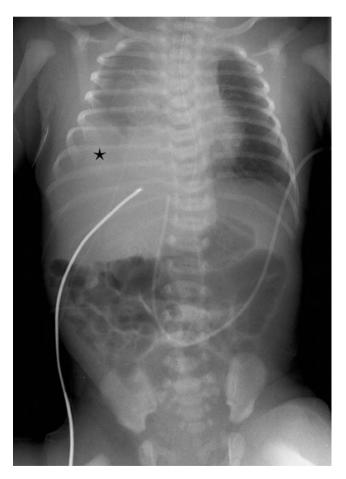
Radiograph of the chest and abdomen shows a small right lung with diffusely decreased aeration. A triangular opacity (*asterisk*) in the lower right hemithorax obliterates the right diaphragm and cardiac border. There is a mediastinal shift to the right
